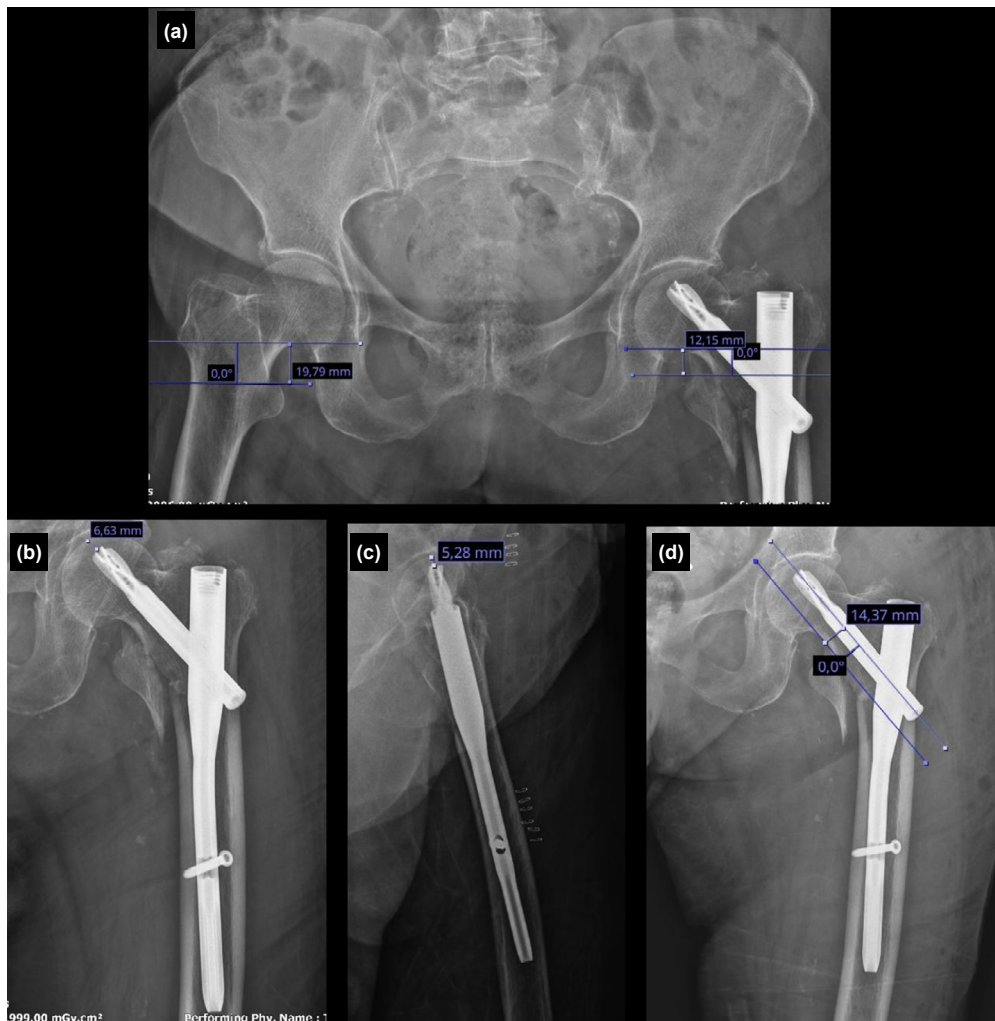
Radiographic measurements for the single-screw type proximal femoral nail (PFN) radiographic measurements. (a) Trochanter minor-calcar distance and normal-side trochanter minor-calcar distance; (b) Anteroposterior proximal lag screw tip-head distance (ApLAG1); (c) Lateral tip-apex distance (LatTAD); (d) Anteroposterior distal lag screw-calcar distance (ApLAG2-calcar distance).
